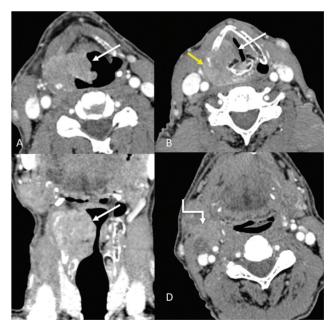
Subglottic involvement. Axial and coronal CT images (A and B) showing subglottic involvement (straight arrows) of the laryngeal
